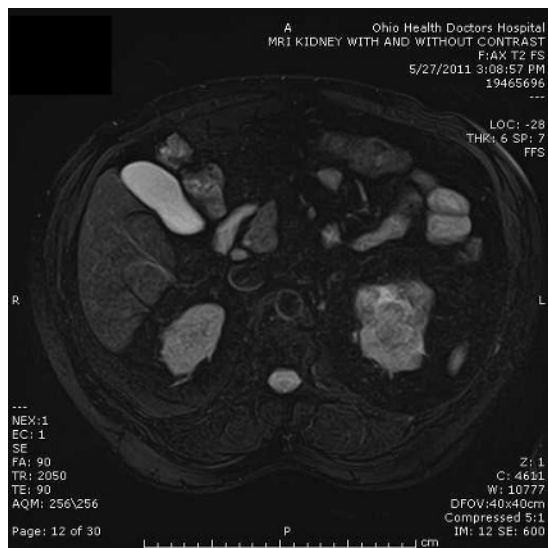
Magnetic resonance image showing a heterogeneous multilobular mass.
